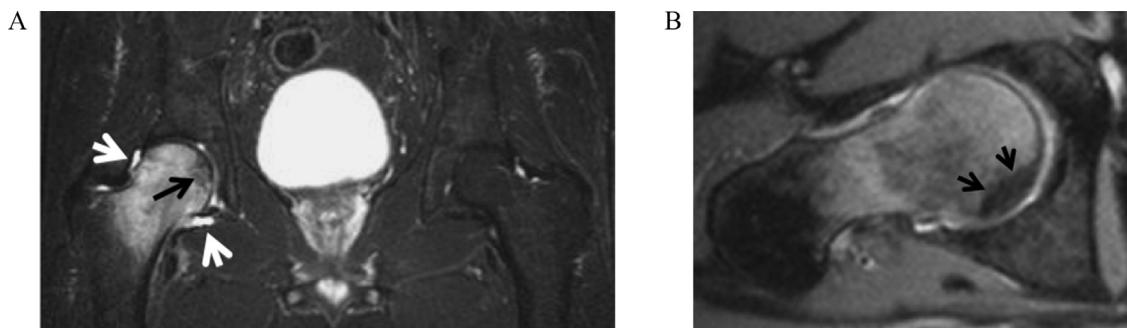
A 51-year-old male patient with a history of 1 week pain prior to the MR imaging examination. The coronal STIR MR image (A) and the oblique axial fat suppressed PD-w MR image (B), show sparing of the medial femoral head bone marrow (black arrows) and joint effusion (white arrows).
